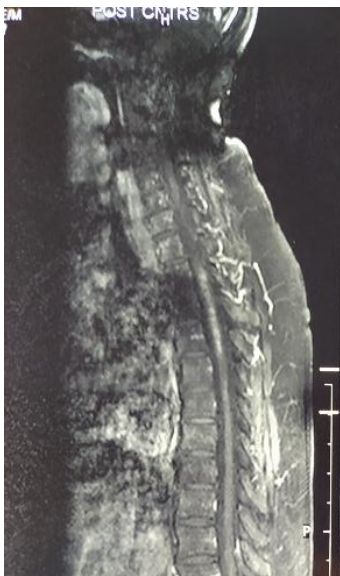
Contrast Sagittal T1-weighted MR image demonstrating heterogeneous mixed signal intensity at T2-T4 with no enhancement
